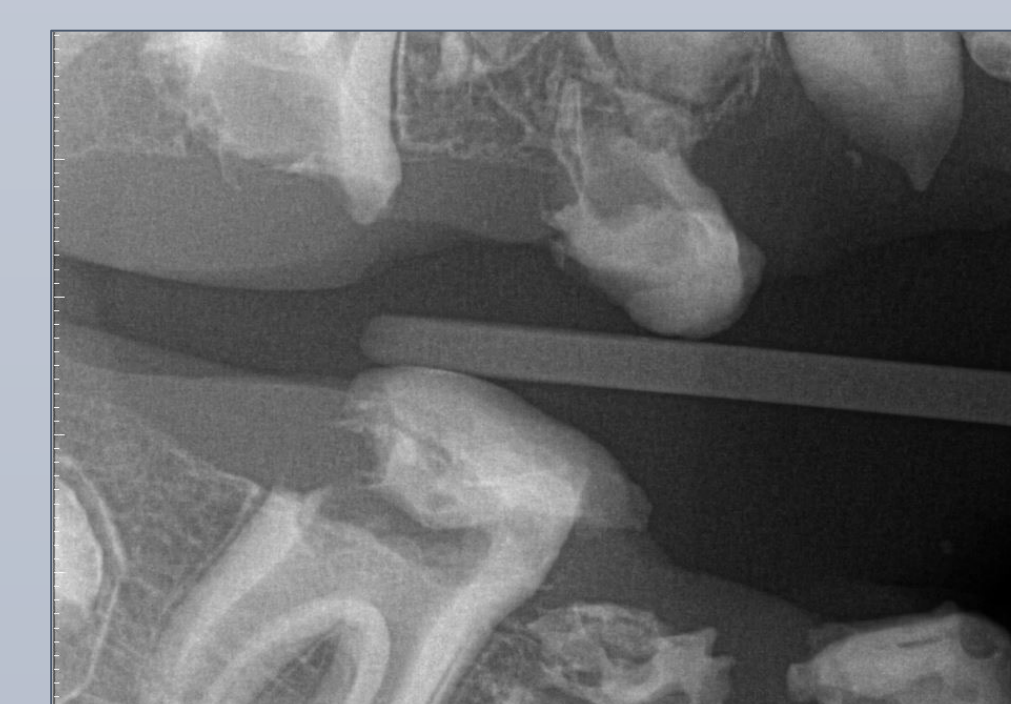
Right Bitewing 4/27/2022
